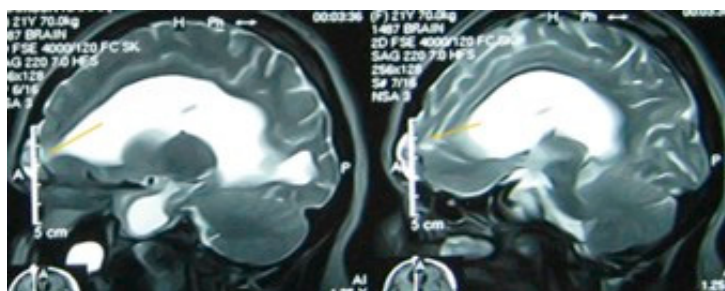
MRI of the brain (T2W sagittal images) showing spontaneous trans-frontal sinus CSF fistula due to chronic increased intracranial pressure (hydrocephalus). Source: Figure by authors.
